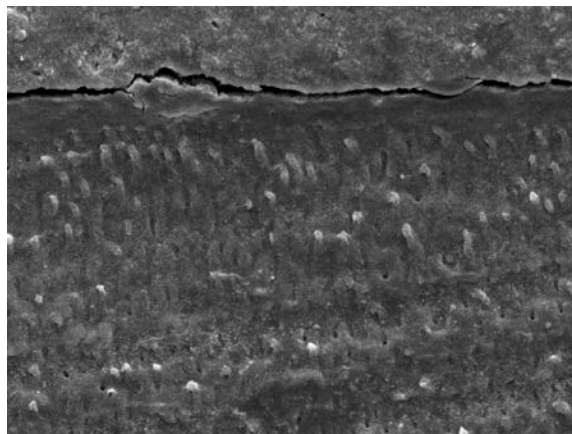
Group 6: The material has adapted well to the dentin surface. (G-Premio Bond adhesive system after Ultrasonic Activation).
